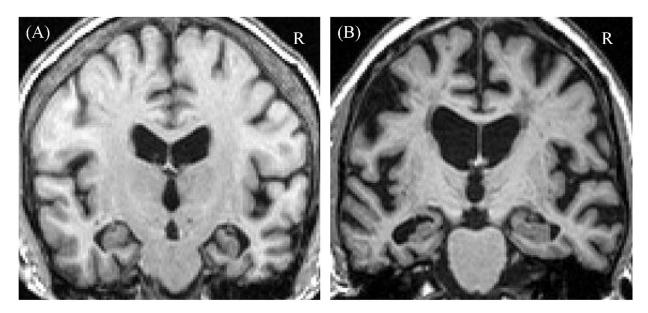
Example MRI Scans Showing Normal Aging and Cortical Atrophy Structural T1-weighted MRI scan for a normal older adult control (A) and a patient with Alzheimer's disease (B) with significant atrophy are shown. Scans are examples taken from data from the Alzheimer's Disease Neuroimaging Initiative (ADNI). MRI-magnetic resonance imaging; R = right
